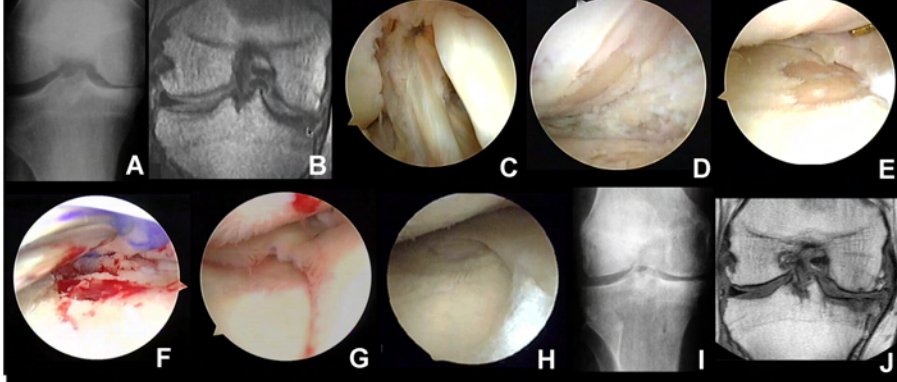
Preoperative, operative, and postoperative images of meniscus allograft transplantation. (a) Preoperative PA flexion radiograph of a 39-year-old male one-year post-meniscectomy with noticeable joint space narrowing (b) Preoperative coronal MRI documenting lateral meniscus bucket handle tear and bipolar cartilage lesions (c) Arthroscopic view of the right knee bucket handle tear displaced into intercondylar notch (d, e) Eburnation of the femoral condyle and tibial plateau (f) Microfracture of the tibial plateau (g) Placement of the meniscus allograft (h) Arthroscopic view of the allograft 17 months postoperatively (i) AP radiograph five years postoperatively showing improved joint space (j) Five-year postoperative coronal MRI revealing the transplanted meniscus present and maturing degenerative changes
